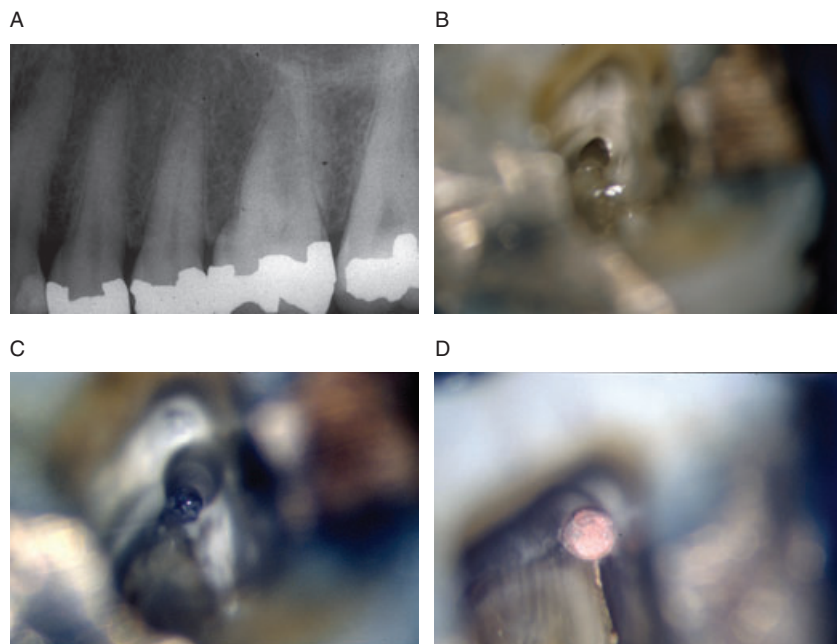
Straight-line access for posterior teeth. A, Pretreatment radiograph of pulpitic tooth #14. B, Dentinal triangle prevents unrestricted access into the MB canal. C, Dentinal triangle removed. D, Straight-line access is achieved. Cleaned and shaped canal is easily obturated.
